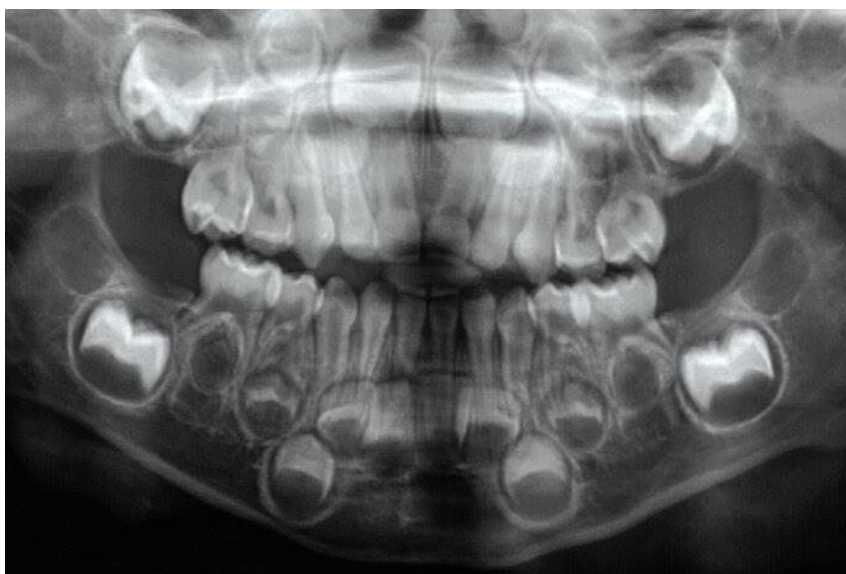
An orthopantomograph showing erupted primary dentition and the permanent dentition within the jaws
